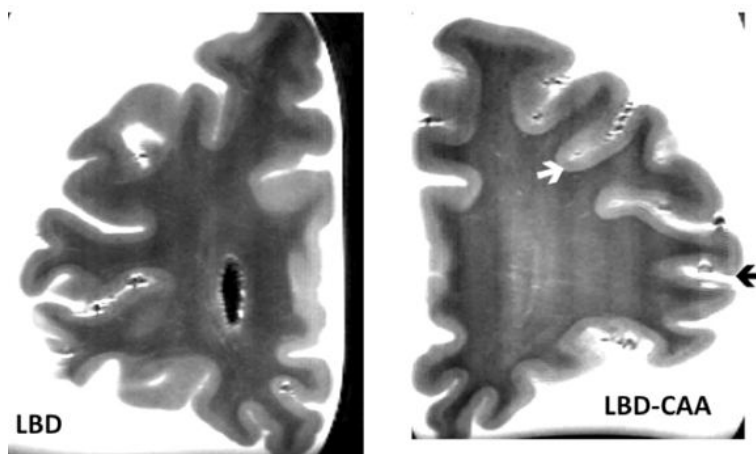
Spin-Echo T2 MRI of frontal sections of Lewy body (LBD) dementia without and with associated cerebral amyloid angiopathy (CAA). The arrows indicate cortical micro-infarcts in the LBD-CAA brains
